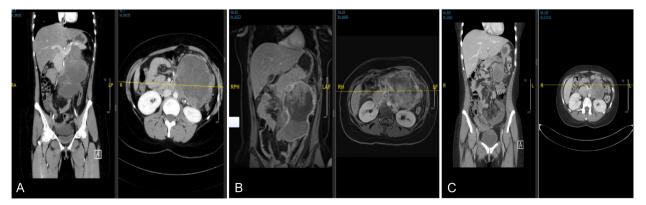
A Computed tomography (CT) of the abdomen and pelvis with contrast revealed retroperitoneal mass.
